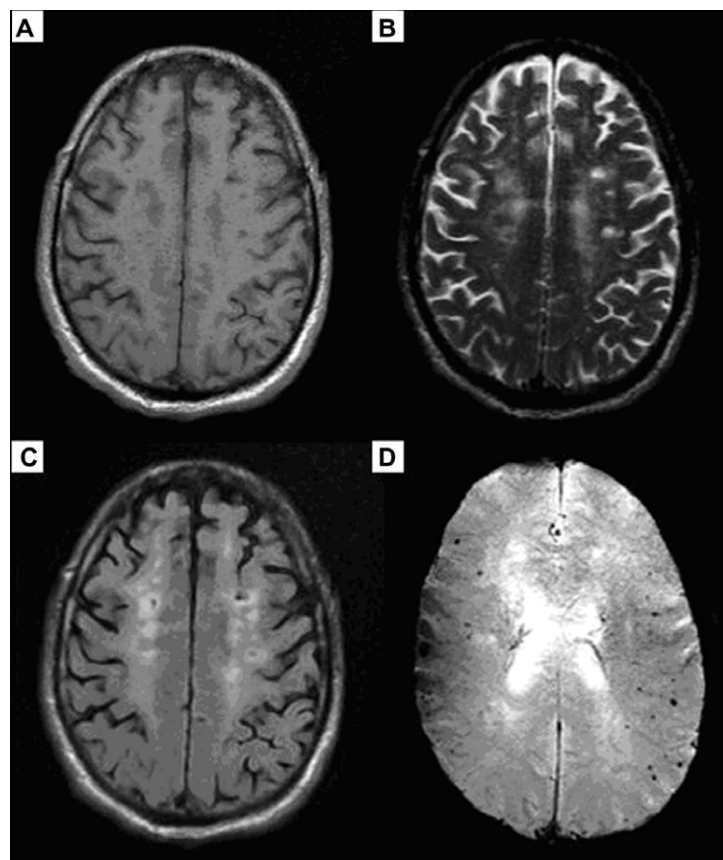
Sixty year old hypertensive male patient presenting with right hemiparesis. While T1 (A), T2 (B) and FLAIR (C) show only lacunar infarcts, SWI (D) reveals foci of hemorrhage in both parietal and frontal lobes matching with chronic hypertensive encephalopathy.
